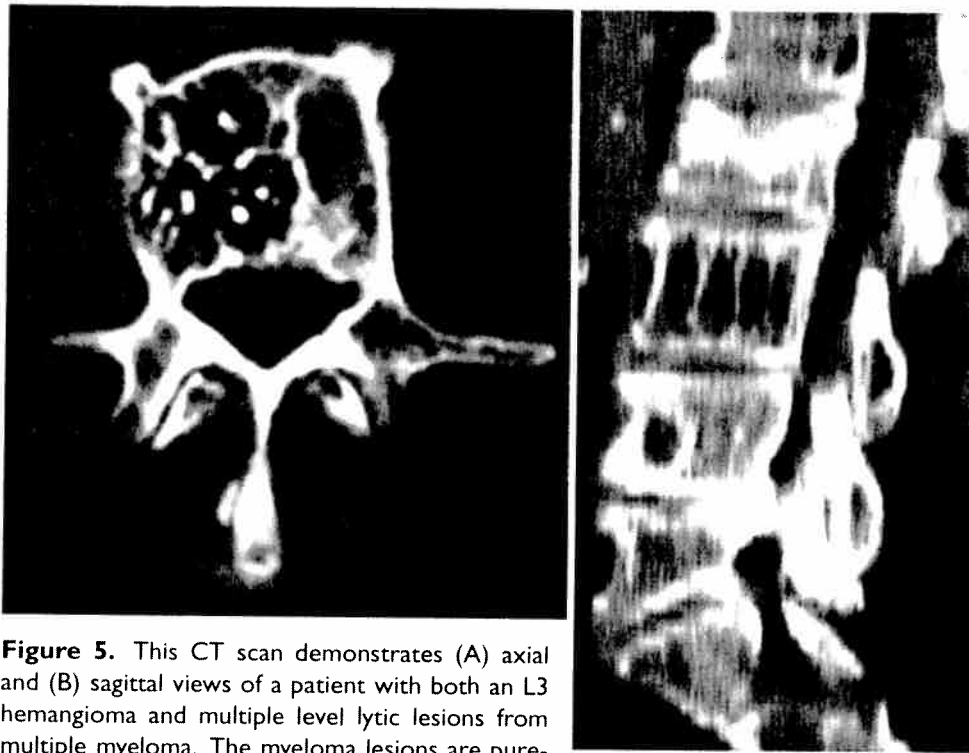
This CT scan demonstrates (A) axial and (B) sagittal views of a patient with both an L3 hemangioma and multiple level lytic lesions from multiple myeloma. The myeloma lesions are purely lytic, the hemangioma demonstrates classic erosions of the horizontal trabeculae with thickening of the vertical trabeculae. On the axial view, this appearance (on the right side of the body) is termed the "polka dot" sign. On the lateral a corduroy appearance or jailhouse striations are noted.
